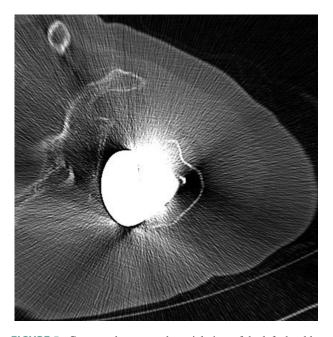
Computed tomography axial view of the left shoulder of patient 1 at last follow-up shows severe posterior subluxation.
